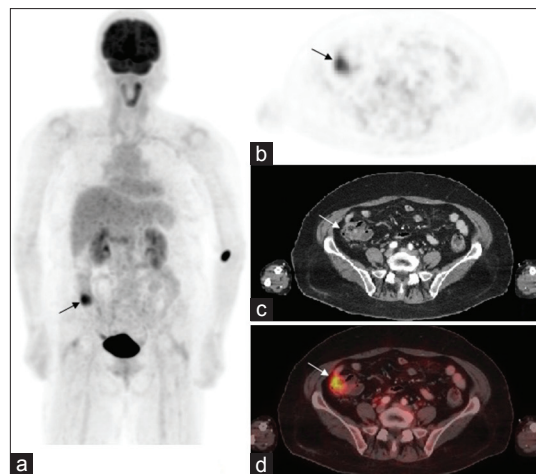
An example of a false-positive focal-fluorodeoxyglucose (FDG) colonic activity in a positron emission tomography/computed tomography (PET/CT) in a patient with history of lymphoma. (a) FDG-PET/CT maximum intensity projection image showing focal FDG activity in the distal cecum (maximum standardized uptake value 7.6). No significant abnormalities were identified in the colonoscopy. (b-d) Respectively the (b) FDG images (c) CT images and (d) hybrid images of this region
